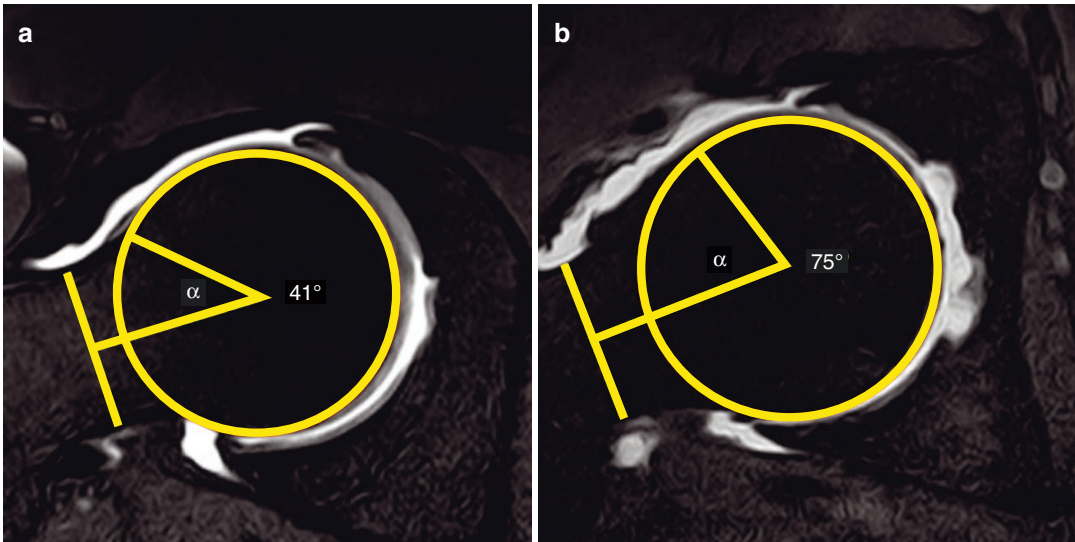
MRI assessment of α -angle using oblique 2.5 mm fat-suppressed T1-wt TSE axial images. (a) Normal hip configuration. (b) A 42-year-old male patient with clinical indication of cam-type femoroacetabular impingement
